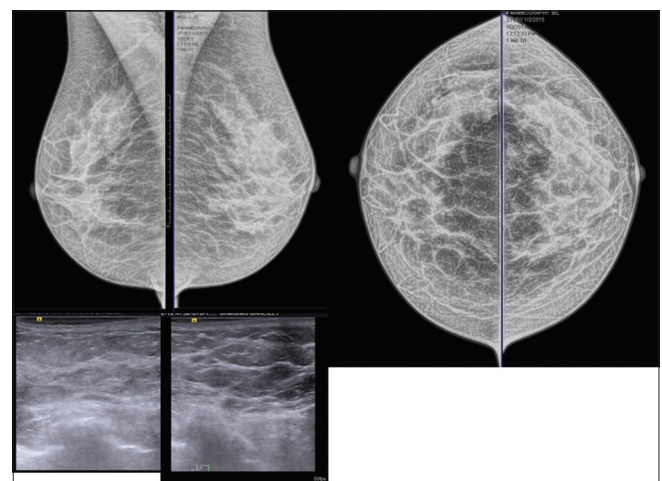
Normal scattered fibroglandular breast pattern and ultrasound images
